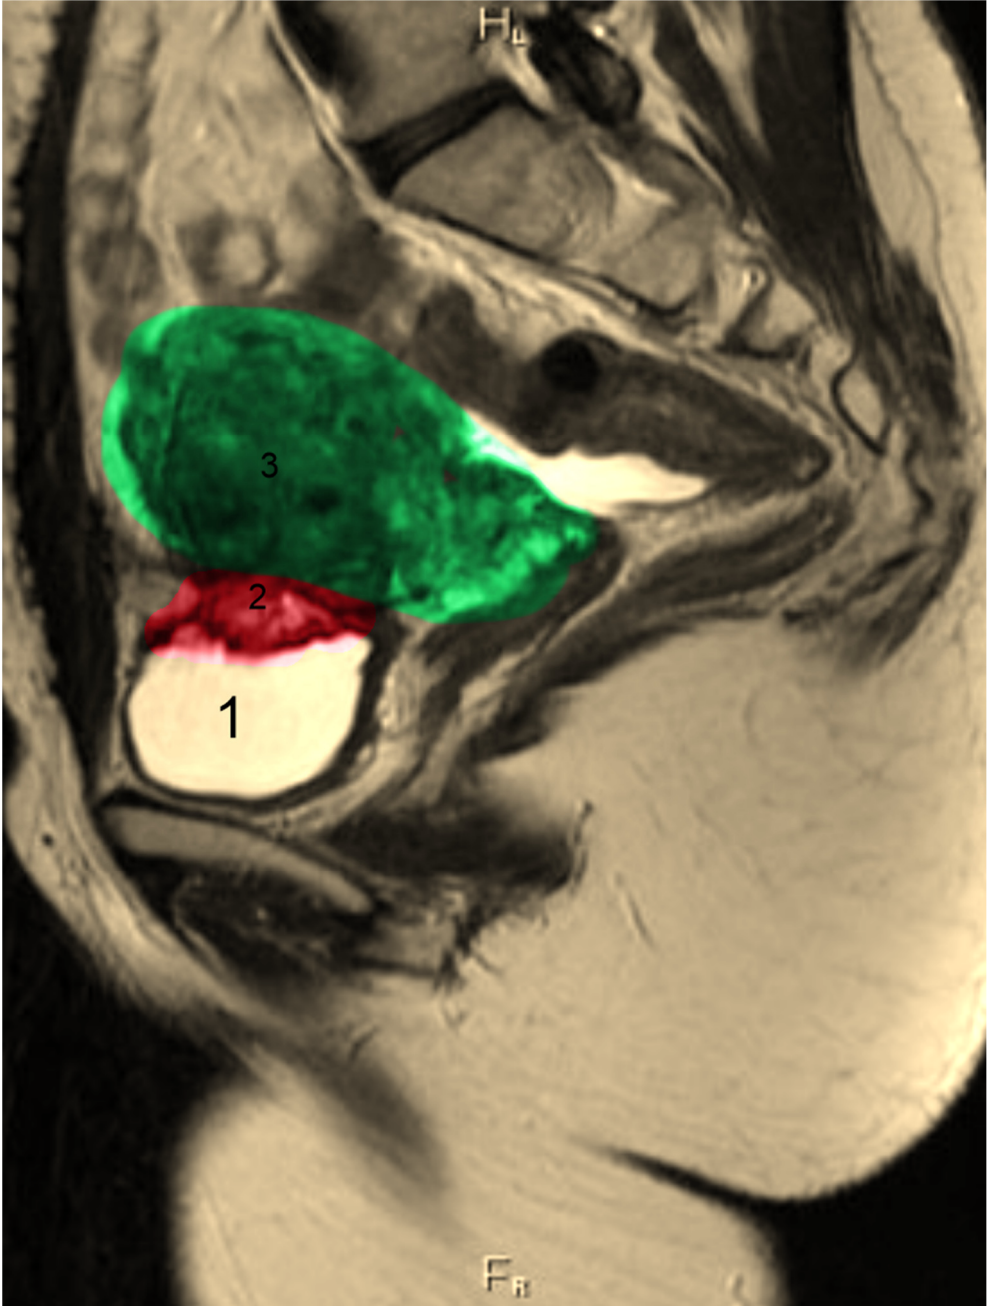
Endometrioma bladder visible on MRI
